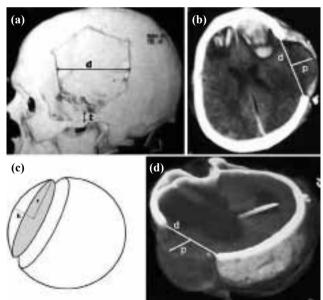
(a) CT reconstruction of a skull after surgery shows craniectomy area; (b) CT scan of a brain after craniectomy shows expanded brain tissue; (c) Figure symbolizes spherical segment above the craniectomy; (d) CT reconstruction of a brain after surgery shows expanded brain tissue as a spherical segment above the craniectomy. d = diameter of the craniectomy, h = height of the perpendicular line (p), p = perpendicular line with the longest distance from the diameter (d) to the dural flap, r = radius of the hypothetical circle (d/2), t = distance of the craniectomy to the temporal cranial base.
